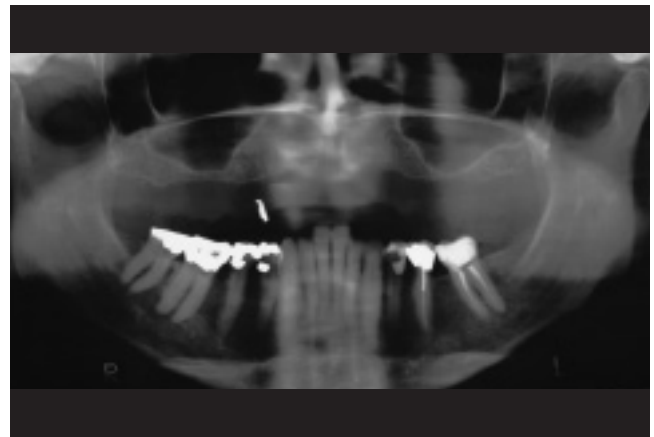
Panoramic radiograph with no observable pathology.
